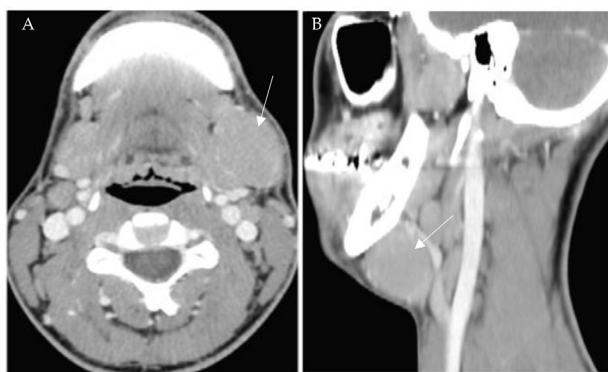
Neck CT scan. A) axial view; B) Sagittal view. Arrow pointing to the mass.
